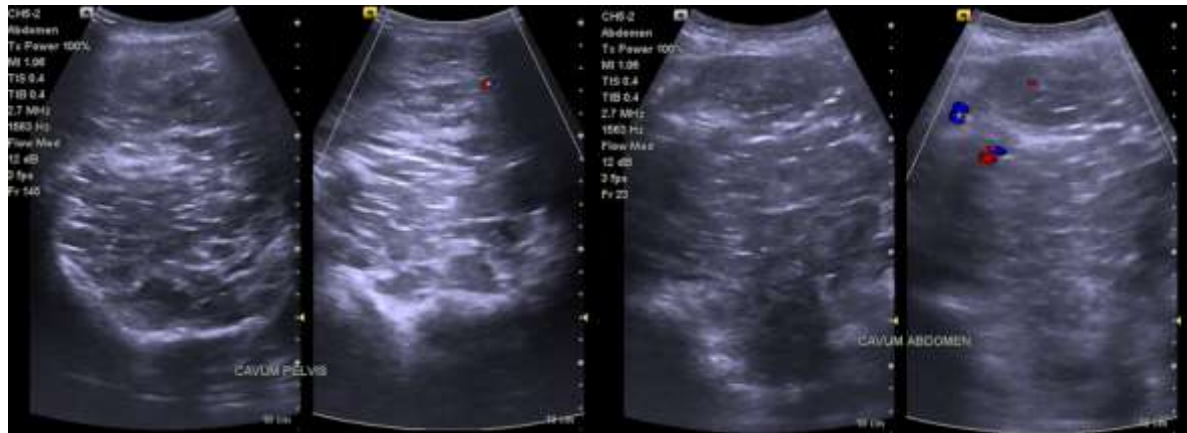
Abdominal ultrasound examination showed the presence of heterogeneous solid masses in the pelvic cavity to the abdominal cavity accompanied by "target-signs" with hyperechoic centers and hypoechoic edges that appear hypovascular in Doppler.
